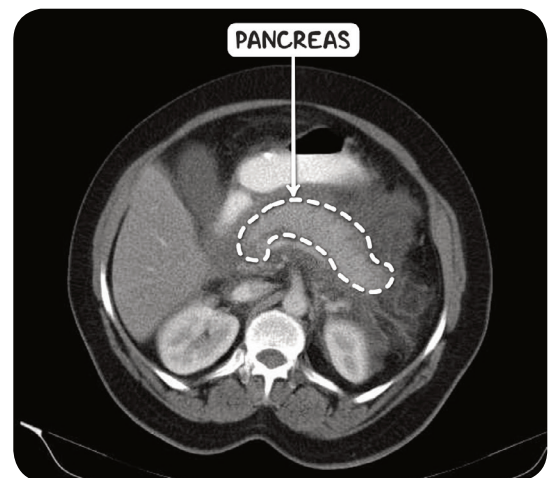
A CT scan in the axial plane demonstrating acute pancreatitis. There is diffuse enlargement of the pancreas associated with peripancreatic fluid.
